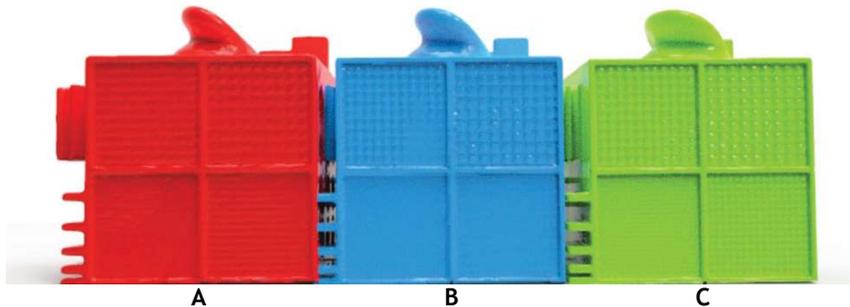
CT Result of Pattern Test Features for 3D Doctor® (A), Mimics® (B) and Invesalius® (C).
